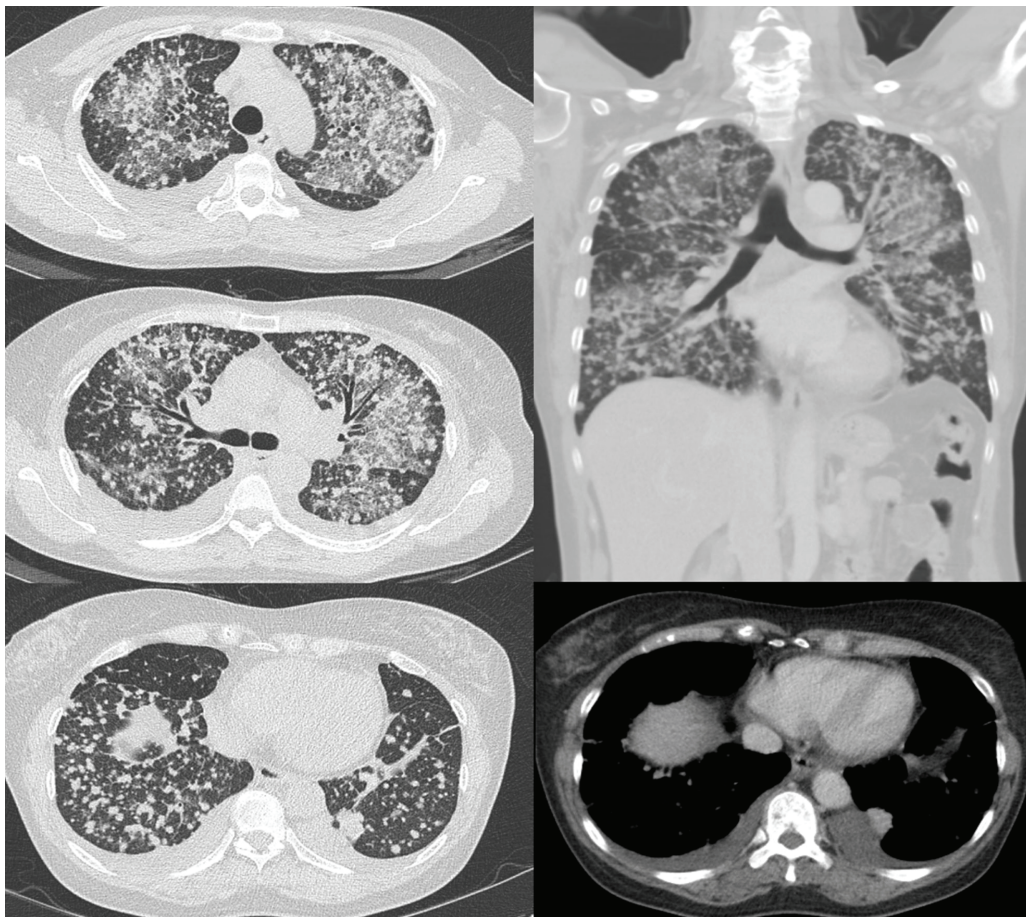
Chest CT scan at the initial diagnosis showed multiple bilateral lung nodules and ground glass opacities (a,b,c), relatively dominant in the left lower lobe and 2.2 cm in size, with a small amount of bilateral pleural effusion (d,e); lymphadenopathy was also seen at the mediastinum and bilateral hilar area.
